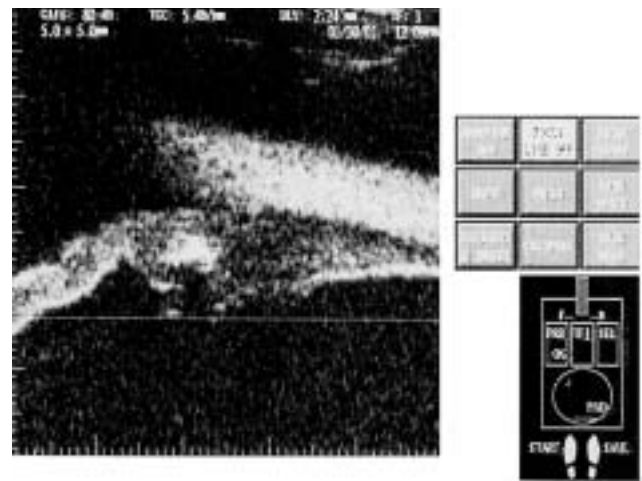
Ultrasound (UBM) of ciliary body tumor.
